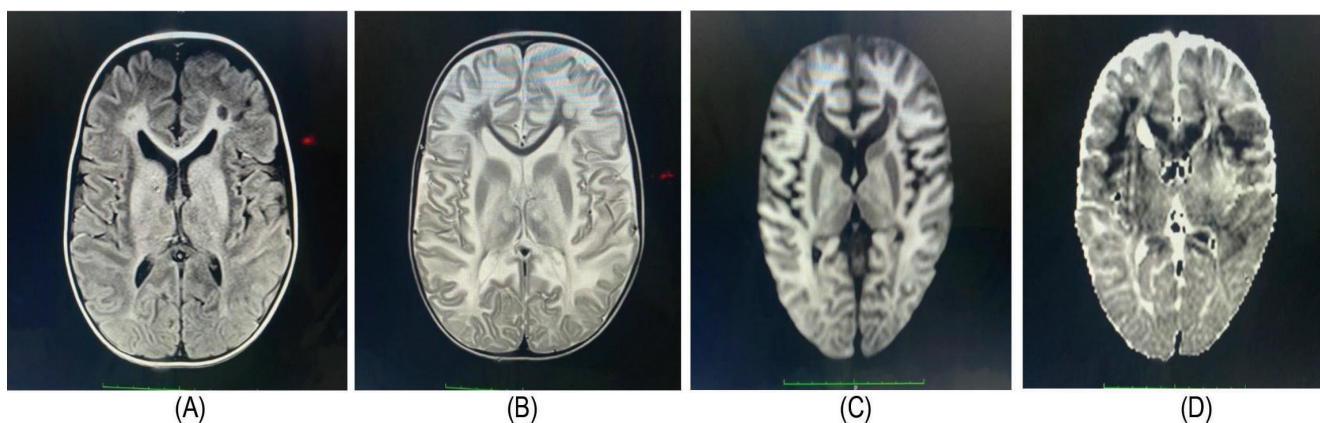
Axial T1W image of Canavan's disease showing hyperintensity involving peri-ventricular & subcortical white matter, thalami & capsular regions on (A), T2W (B) and showing diffusion restriction on DWI (C), low signal on ADC (D).
